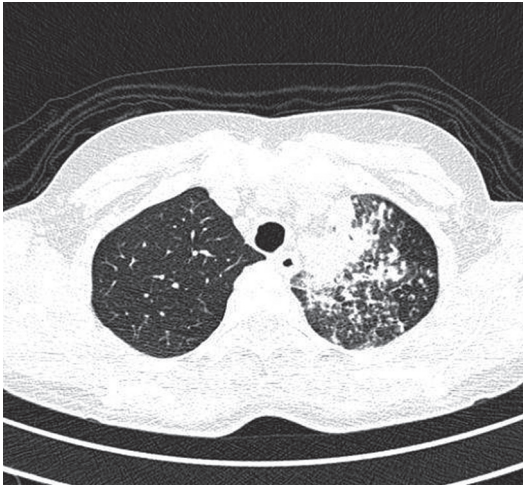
Chest CT scan revealing tree-in-bud centrilobular opacities predominantly in the upper portions of the left lung.
